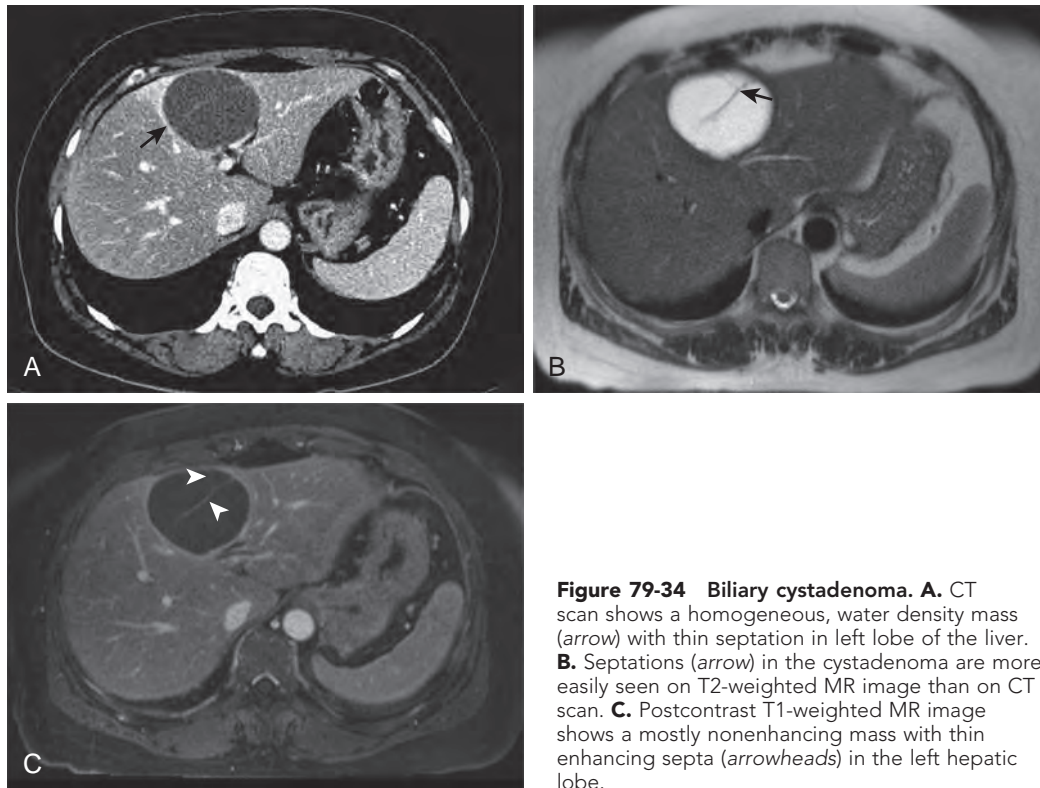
Biliary cystadenoma. A. CT scan shows a homogeneous, water density mass (arrow) with thin septation in left lobe of the liver. B. Septations (arrow) in the cystadenoma are more easily seen on T2-weighted MR image than on CT scan. C. Postcontrast T1-weighted MR image shows a mostly nonenhancing mass with thin enhancing septa (arrowheads) in the left hepatic lobe.
